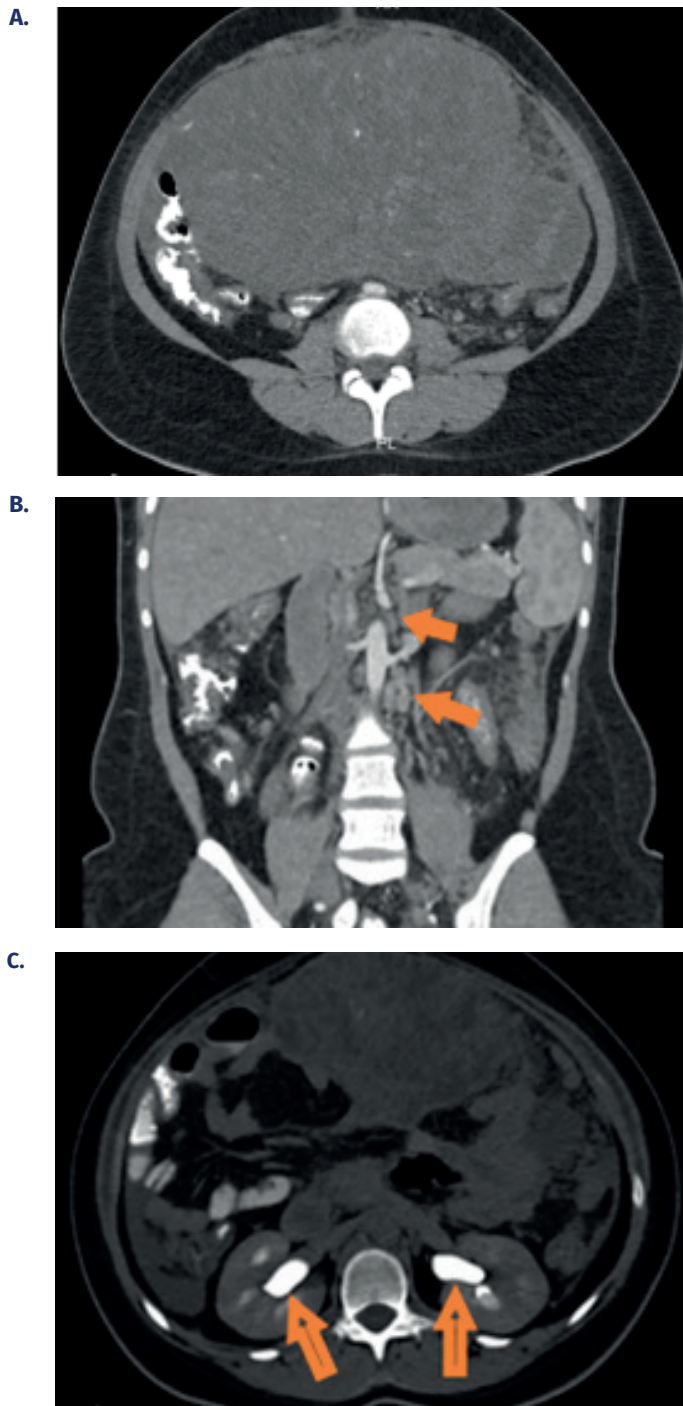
Computed tomography of the abdomen and pelvis. A. Large, predominantly solid abdominopelvic mass with heterogeneous enhancement and cystic/necrotic areas, measuring 20.5 cm × 13.8 cm × 23.9 cm, causing mass effect on adjacent structures and showing evidence of free fluid. B. Diffuse decrease in density related to steatosis. The inferior vena cava and the iliac venous axis appear compressed by extrinsic pressure, without obvious thrombosis. Both kidneys look normal in shape, size, and density. C. Mild bilateral pyelocaliceal ectasia likely caused by extrinsic compression of the mid-ureters. Homogeneous splenomegaly with a maximum longitudinal diameter of 13.9 cm.
